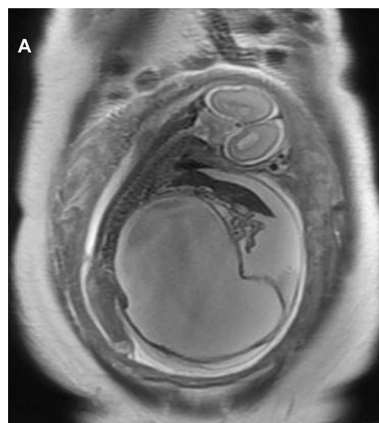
A & B: Fetal MRI confirmed moderate free fluid in the peritoneal cavity with severe oligohydramnios. Fetal abdominal wall is severely thinned out. Large cystic structure involving abdomino-pelvic cavity representing grossly dilated urinary bladder. The right renal pelvis is moderately dilated. The dilated ureter is seen opening in the lateral wall of the urinary bladder. Left renal parenchyma shows altered signal intensity
